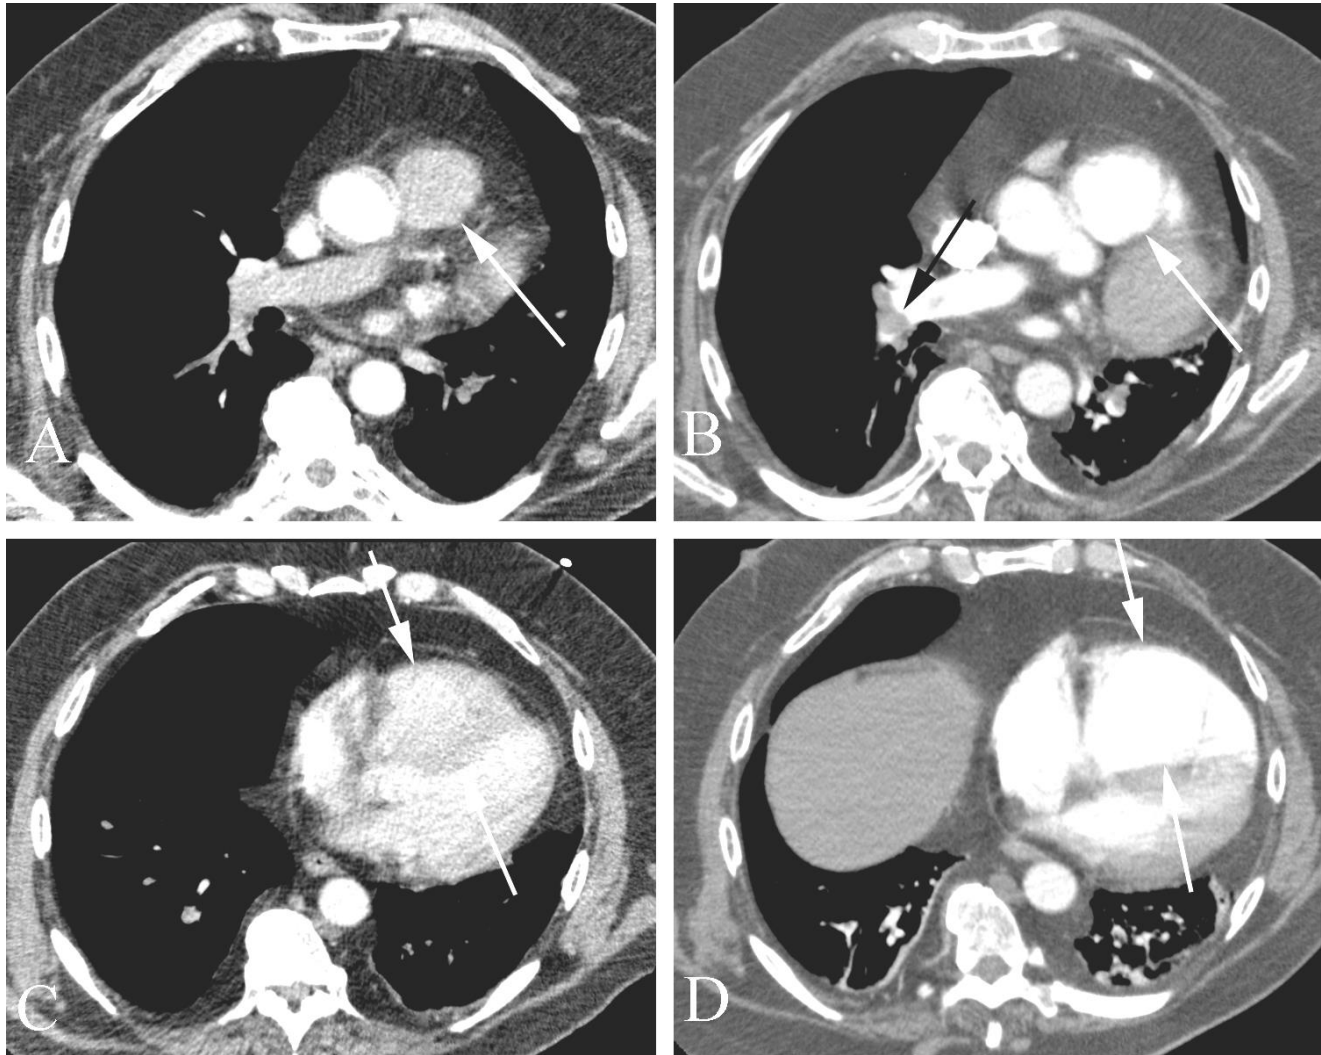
Pulmonary embolism in a 61 year old man with acute shortness of breath following recent abdominal surgery. A. Axial contrast-enhanced CT months before the patient's PE shows a normal sized main pulmonary artery (arrow). B. Axial contrast-enhanced CT shows a filling defect in the right pulmonary artery (pulmonary embolism) (black arrow) along with a dilated main pulmonary artery (white arrow). C. Axial contrast-enhanced CT at the level of the right ventricle months before the patient's PE shows a normal sized right ventricle (between arrows) D. Axial contrast-enhanced CT following the patient's pulmonary embolism shows a dilated right ventricle. An enlarged right ventricle is a poor prognostic sign in patients with pulmonary embolism.
